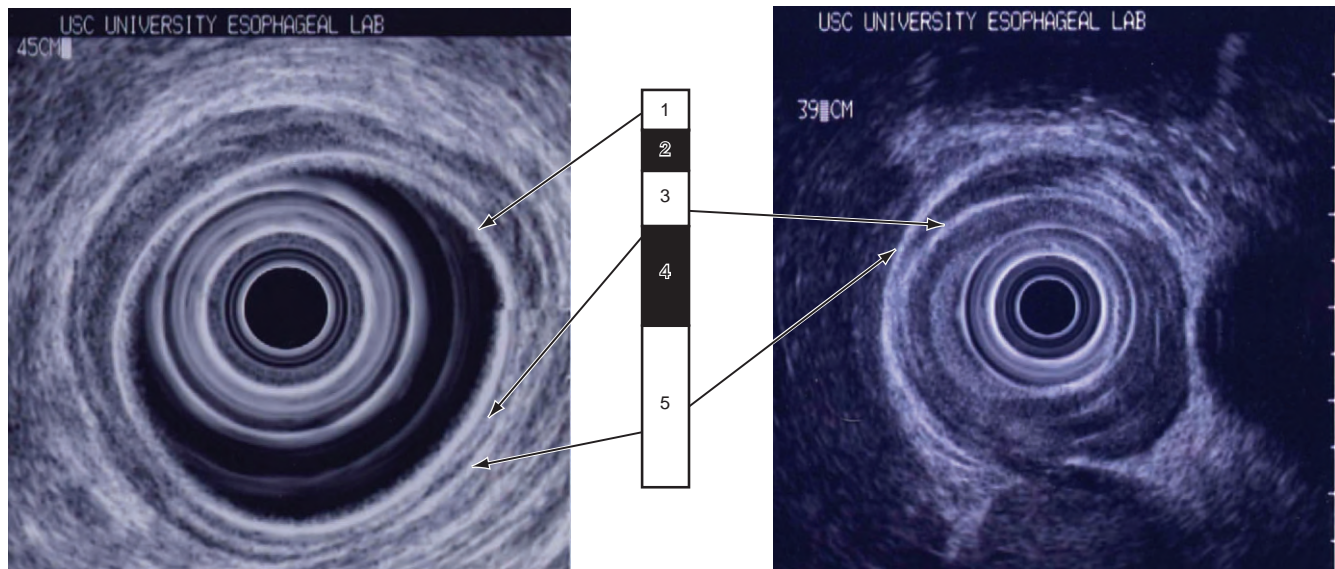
Endoscopic ultrasound appearance of a normal esophagus (*left*) and a T3 esophageal cancer (*right*). The layers of the esophagus appear as alternating white (hyperechoic) and black (hypoechoic) rings. The first hyperechoic layer represents the mucosa (epithelium and lamina propria). The first hypoechoic or black ring represents the muscularis mucosa. The third layer is hyperechoic and represents the submucosa. The fourth layer is hypoechoic and identifies the muscularis propria. The last layer is hyperechoic and identifies periesophageal tissue. The tumor seen at 4 o'clock shows disruption of the third and fifth layers.
